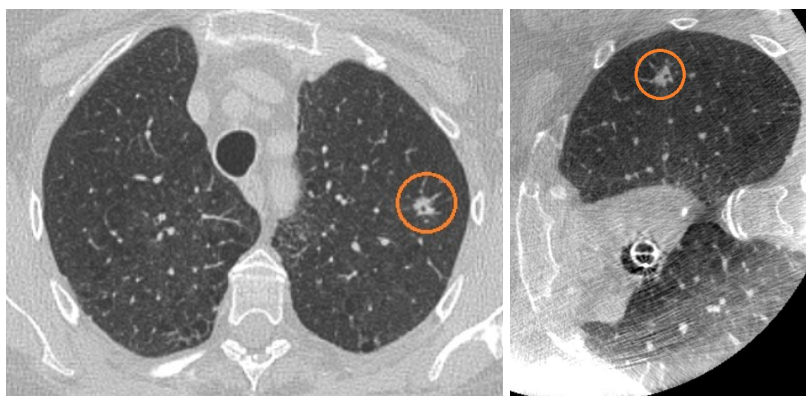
Slices in approximately the same transversal plane for preoperative CT (supine position) and intraoperative CBCT (lateral decubitus position). The nodule is encircled in orange. The change of configuration from preoperative to intraoperative configurations is clearly visible.
